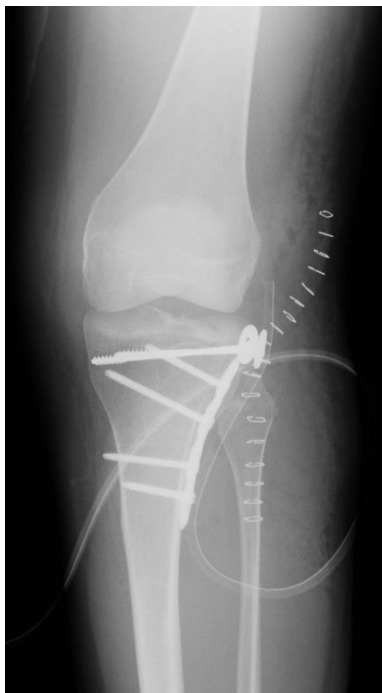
AP postoperative X-ray
